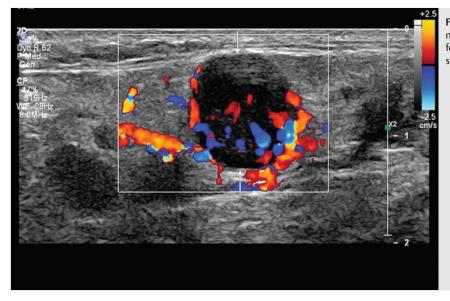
Color Doppler ultrasound image showing mixed peripheral-central flow in a lymph node, a feature favoring malignancy. Also, note the round shape of the node (*arrows*).
